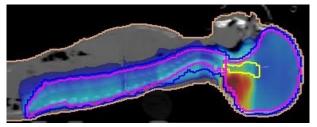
Isodosecurve show on CT image of both plans
